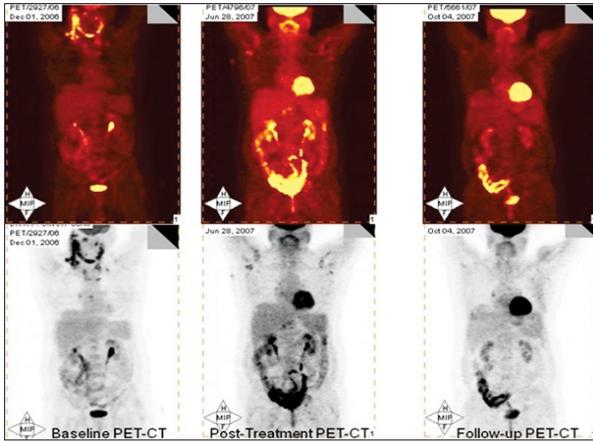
FDG PET-CT of 21/F patient with HD showing residual normal in post-chemo PET-CT, which also normal in follow-up PET-CT (Responder)*
